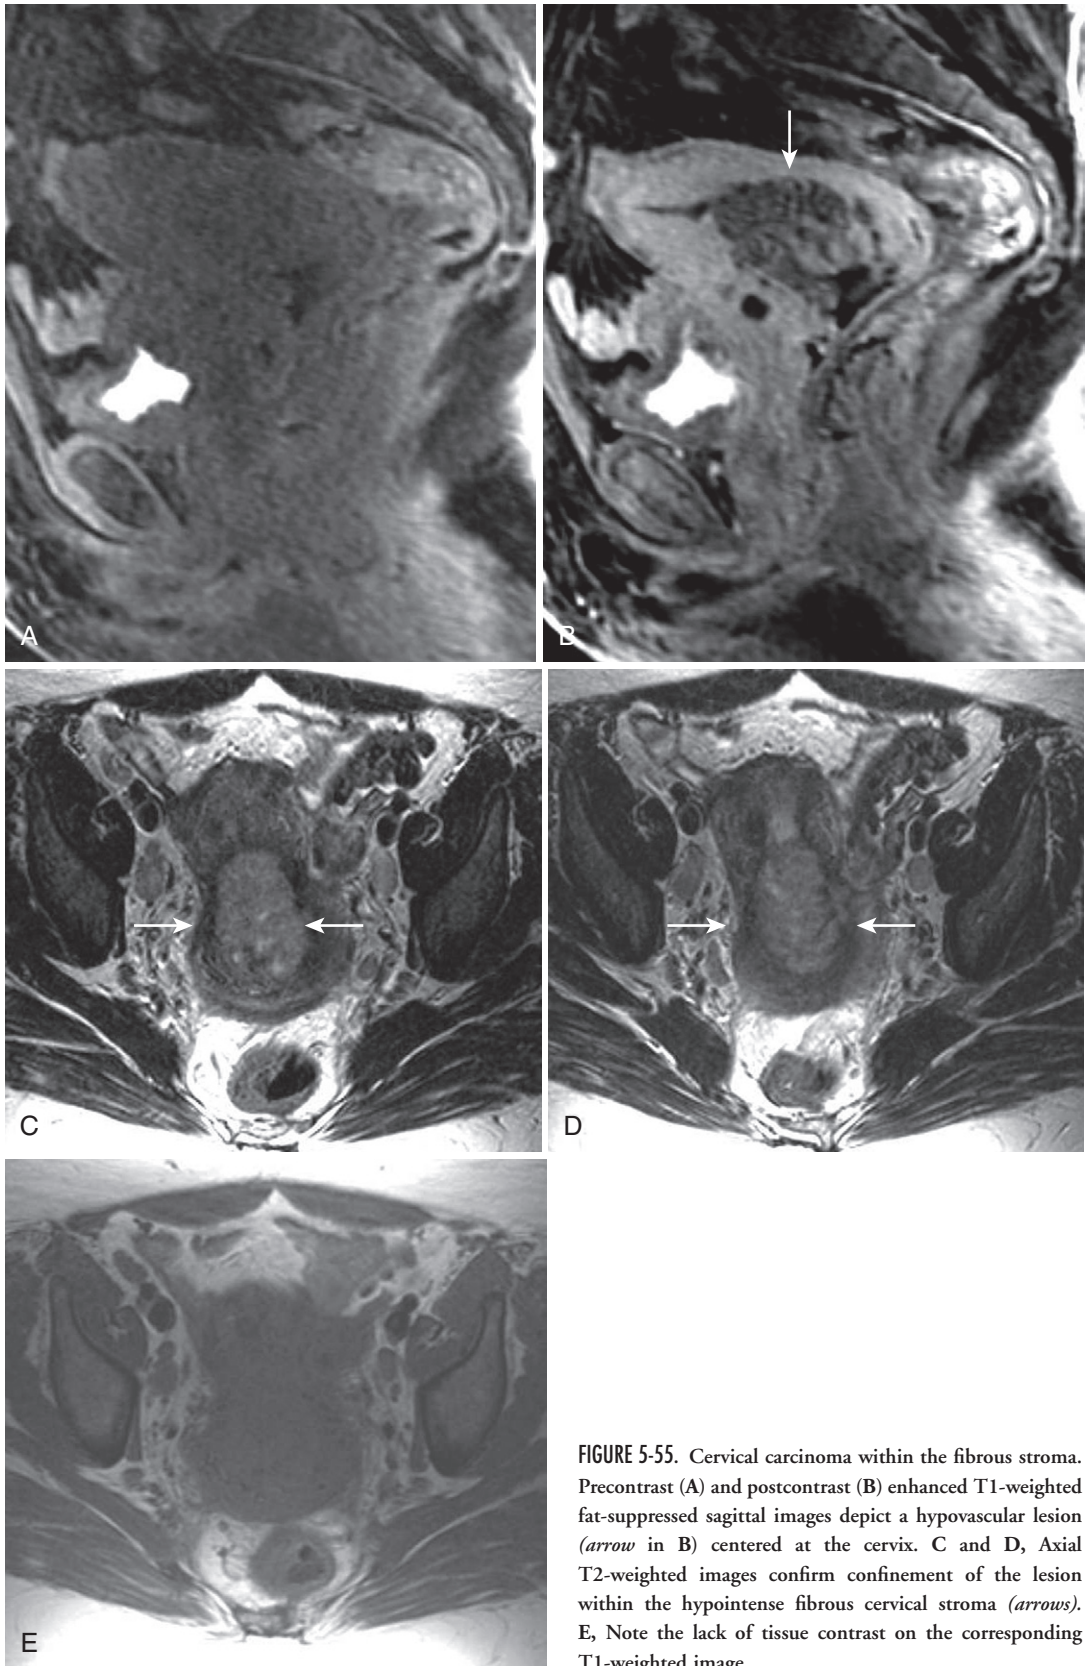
Cervical carcinoma within the fibrous stroma. Precontrast (A) and postcontrast (B) enhanced T1-weighted fat-suppressed sagittal images depict a hypovascular lesion (arrow in B) centered at the cervix. C and D, Axial T2-weighted images confirm confinement of the lesion within the hypointense fibrous cervical stroma (arrows). E, Note the lack of tissue contrast on the corresponding T1-weighted image.
